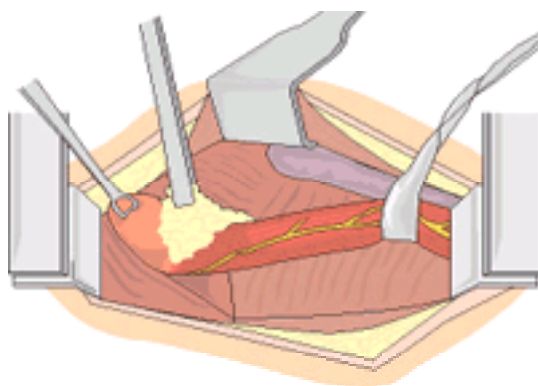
Transthoracic Nissen fundoplication. (1) Through a left posterolateral thoracotomy, the esophagus is mobilized and the gastroesophageal junction is dissected from the diaphragmatic hiatus. The fundus of the stomach is drawn into the chest using a Babcock clamp. The forceps are on the vascular fat pad at the gastroesophageal junction.
